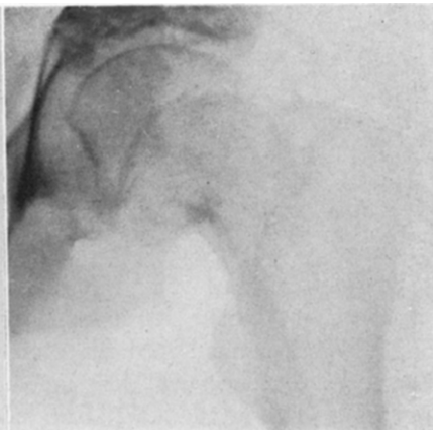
Case XIII. Roentgenogram three months after drilling, May 7, 1932; maintained continuity between head and neck; definite primary compression focus in head.
